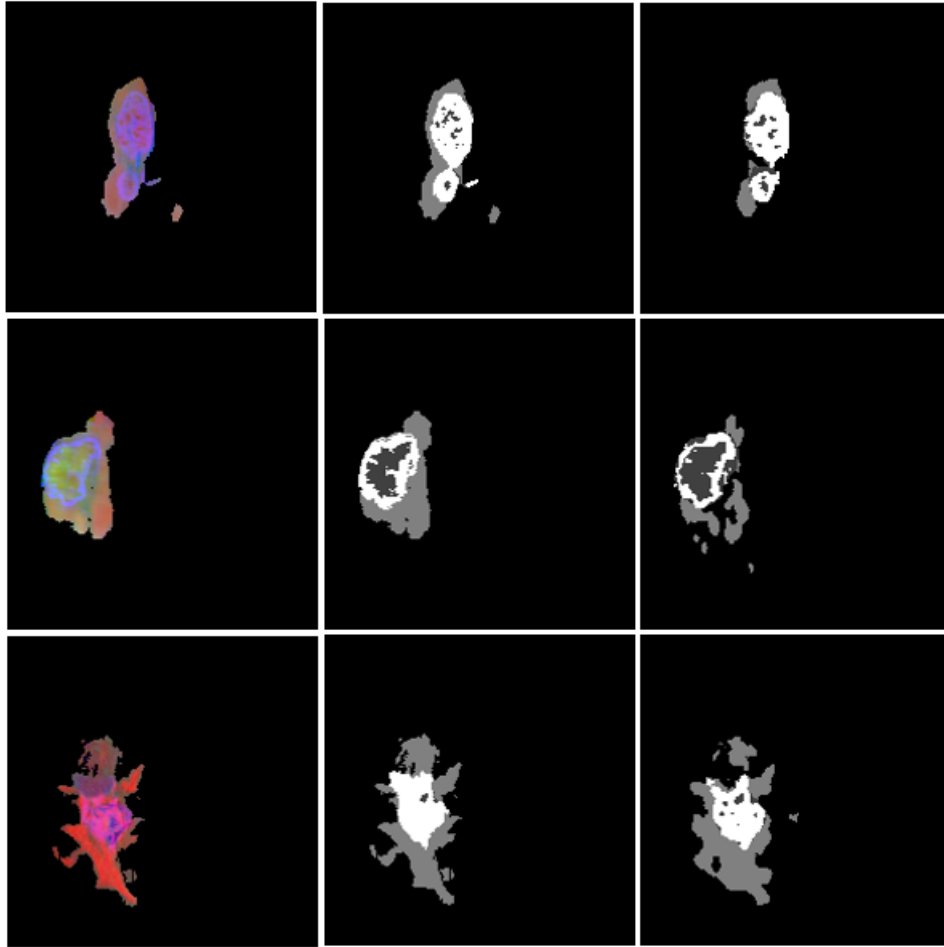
(a) Combined MRI modalities, (b) ROI mask images and (c) MRI ROI images.
